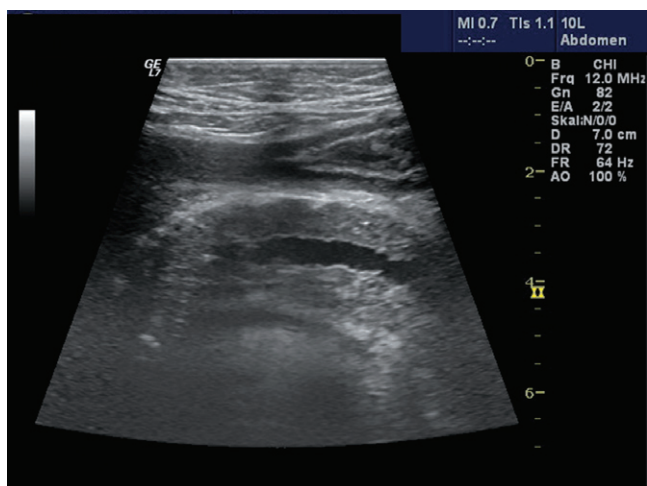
Pancreatic duct alterations in chronic pancreatitis. Transabdominal ultrasound: dilated irregular main pancreatic duct.
